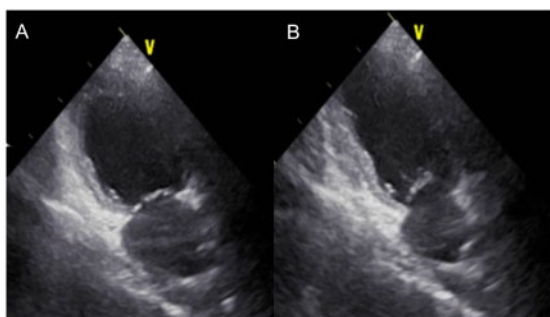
Transthoracic echocardiography in two-chamber view showing severe akinesis of the basal and mid segments with apical sparing. (A) Systolic phase. (B) Diastolic phase.
